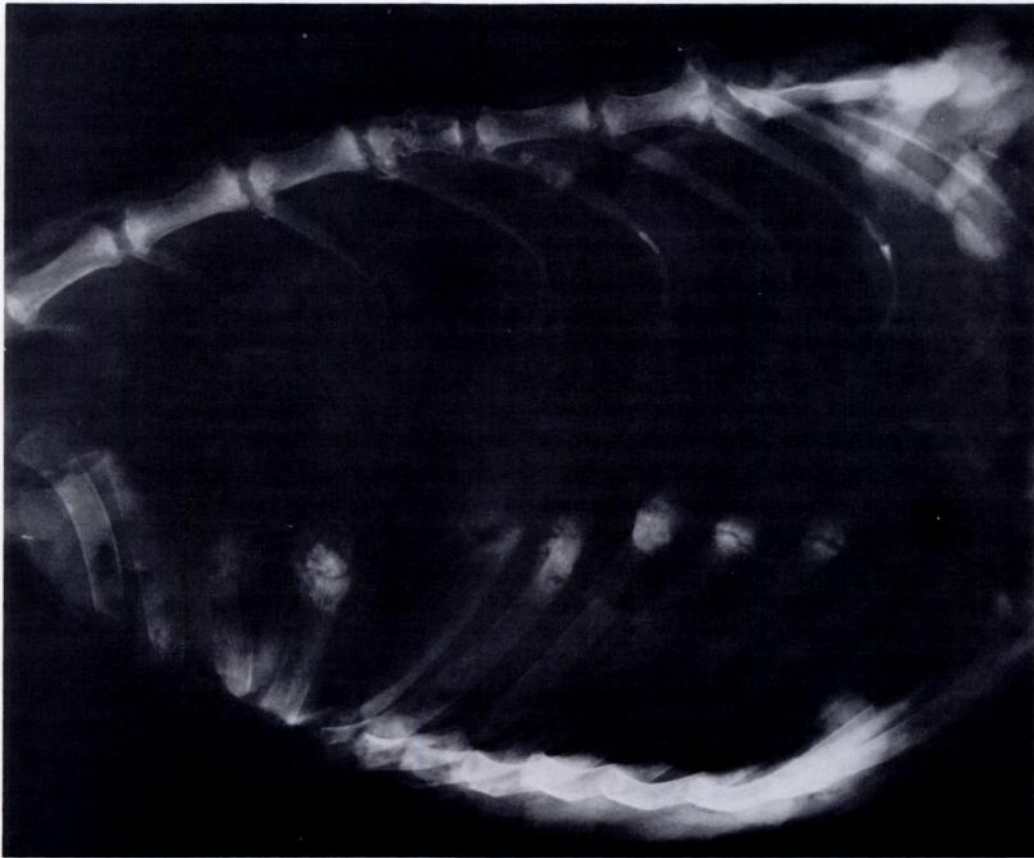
Radiograph of right thorax of a captive maned wolf showing recent and old, partially-healed rib fractures and poorly mineralized calluses. Note also fracture of vertebral body.
